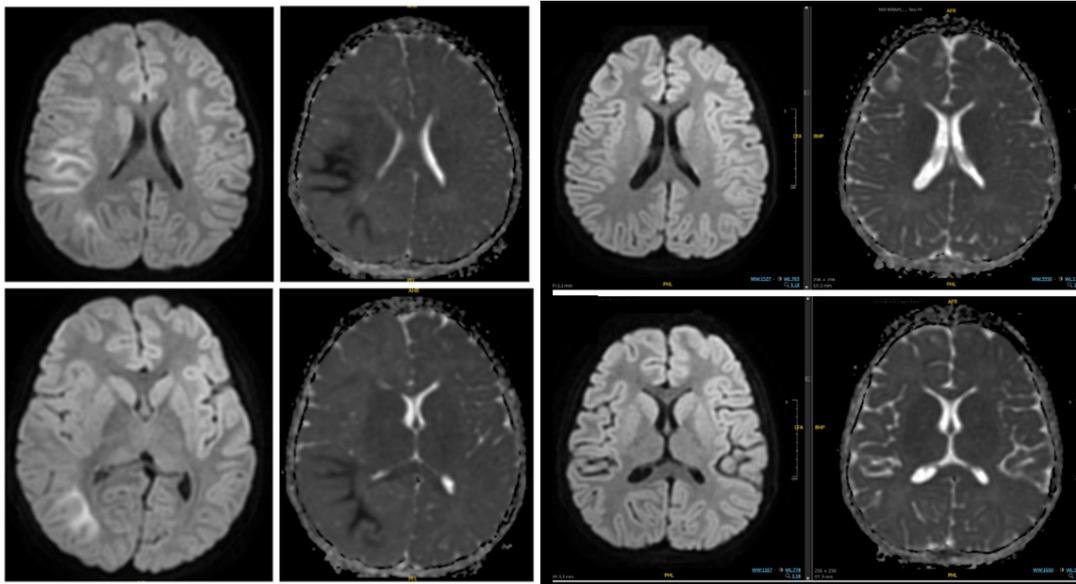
DWI/ADC images on day 8 of illness (left) and day 66 post-treatment (right) showing cytotoxic oedema in the right parieto-temporo-occipital region and subsequent resolution.
